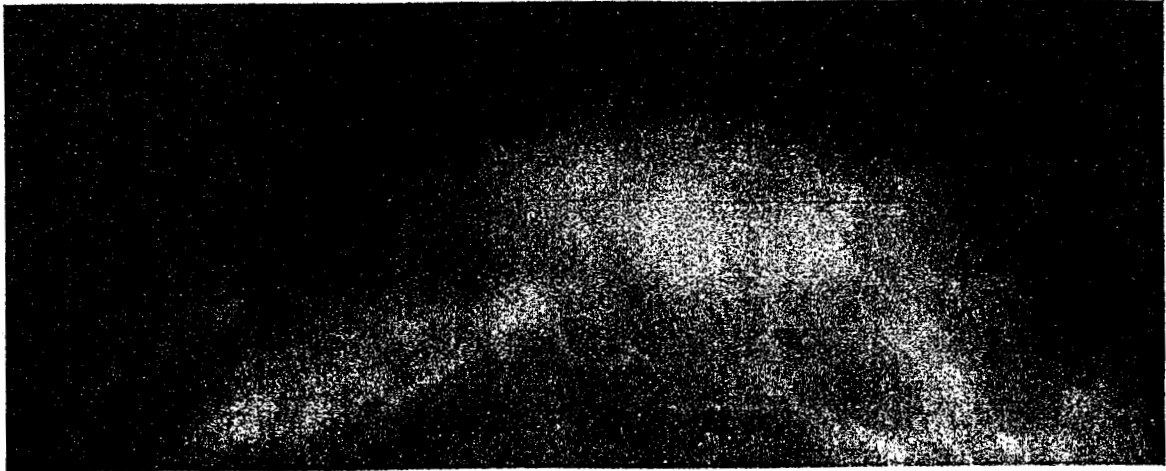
(a) Right breast, x-ray image.
